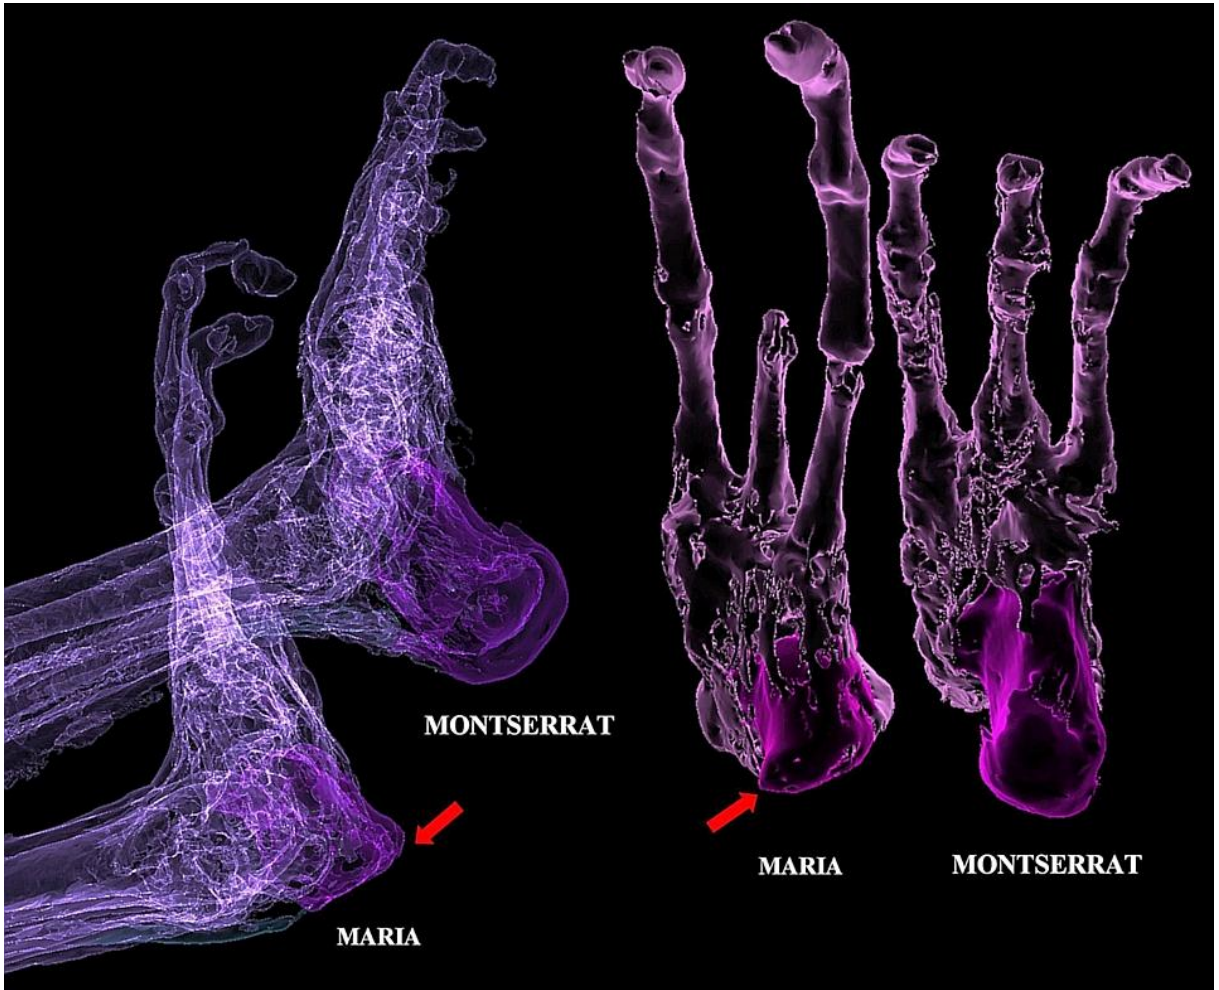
Comparison of 3D CT in semi-transparency between the heels of Maria and Montserrat. Noted the truncated posterior part of the calcaneum of Maria showed very thin bony cortex (*red arrow*) with sharp margin relative to the rest of calcaneum contrasting with the relatively thick cortex and rounded appearance in Montserrat.
